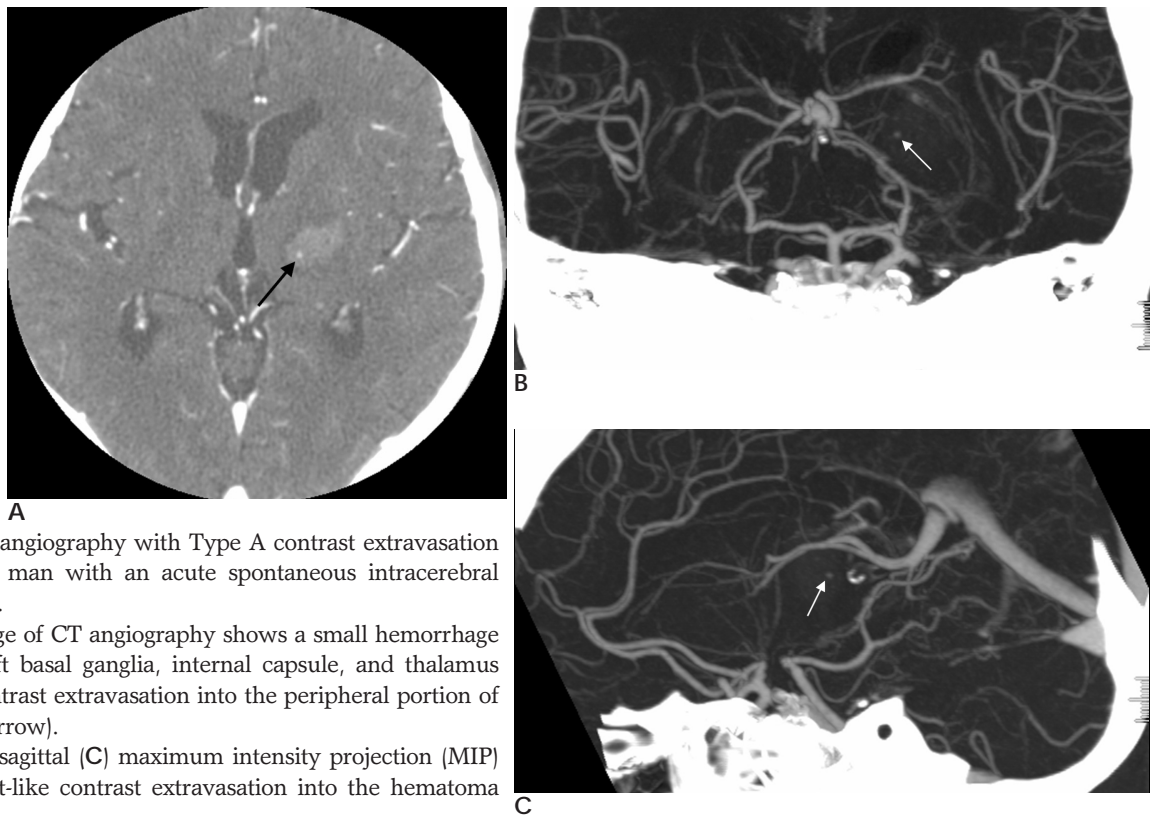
Brain CT angiography with Type A contrast extravasation in a 51-year-old man with an acute spontaneous intracerebral hematoma (ICH).
